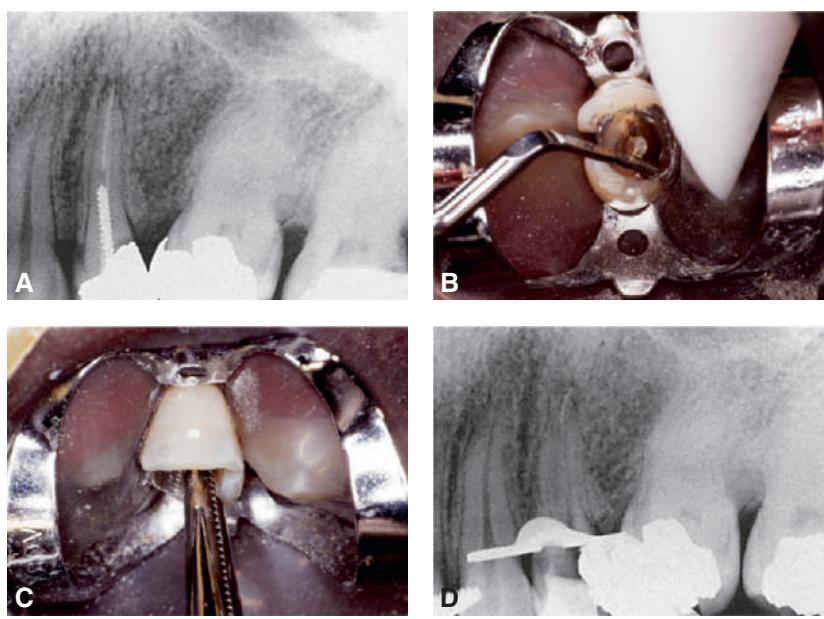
Post removal by ultrasonic device. (A) Preoperative radiograph of the left maxillary first premolar with a parallel-sided threaded post that had to be removed for endodontic re-treatment. (B) After the coronal portion of the post has been well isolated, the tip of the ultrasonic device is placed against it, and energy is applied to disrupt the cement interface. Note the suction tip, which removes water spray used with the ultrasonic handpiece. (C) After a time, the post becomes loose within the canal and can be retrieved by forceps. (D) Radiograph of the premolar after post removal. (Courtesy Dr. L.L. Lazare.)
